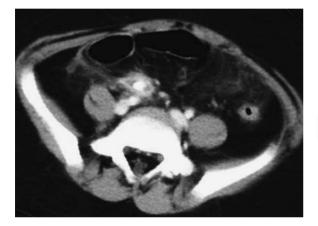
CT of the lower abdomen showing a swollen appendix containing an appendicolith and with adjacent stranding of the intraperitoneal fat
